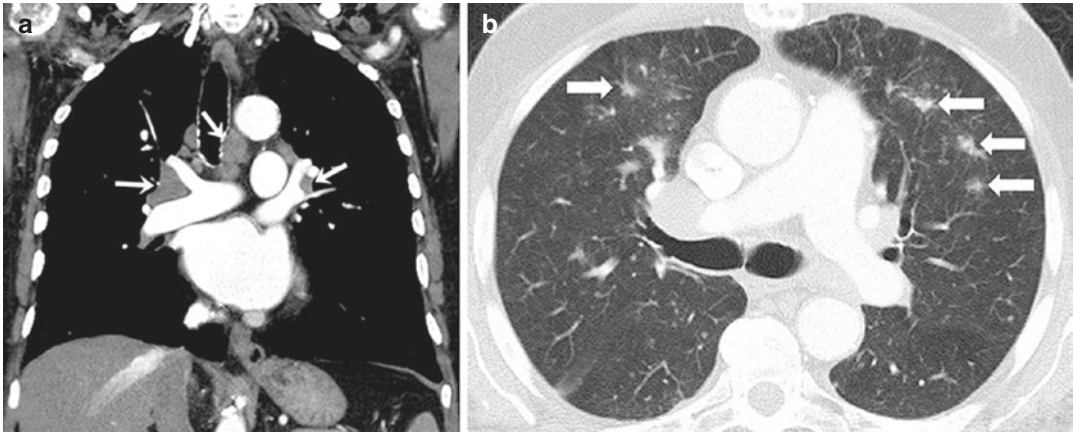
Sarcoid-like lymphadenopathy in an asymptomatic 81-year-old man with metastatic melanoma treated with ipilimumab. (Reprinted with permission from *Cancer Immunol Res.* 2015 Oct;3(10):1185–92). (a) Coronal reformatted contrast-enhanced chest CT performed 4.9 months after the initiation of ipilimumab therapy showed new bilateral symmetric mediastinal and hilar
